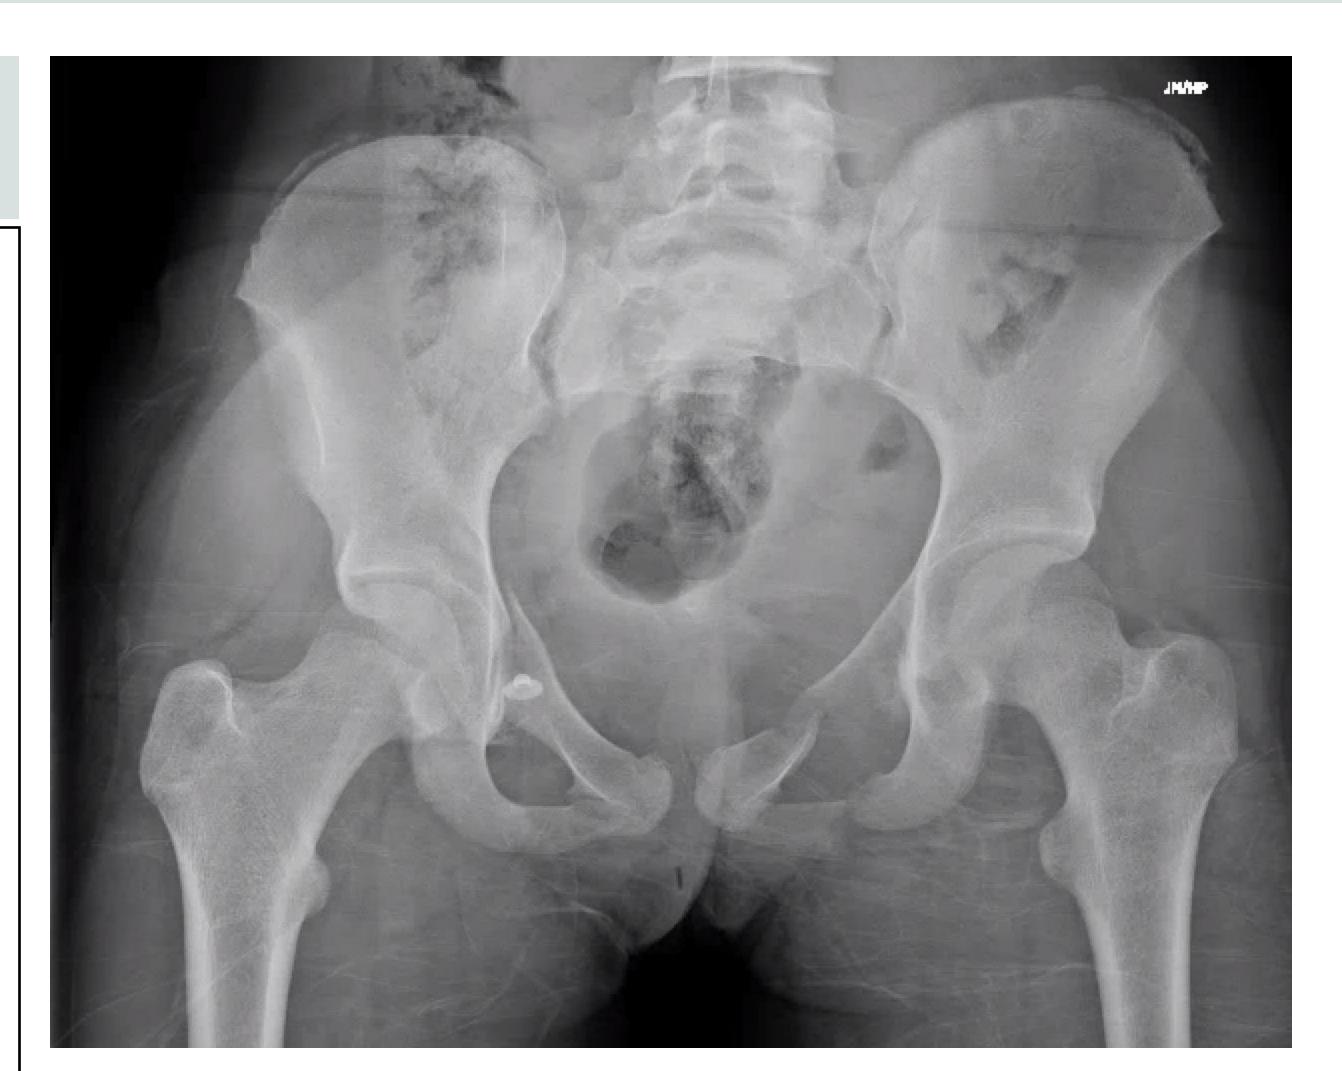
Preoperative anteroposterior (AP) pelvic radiograph showing bilateral pelvic ring disruption with left posterior column acetabular and sacral ala fractures, and right lateral compression—type injury with anterior column fracture, sacroiliac joint widening, and right sacral ala involvement.
